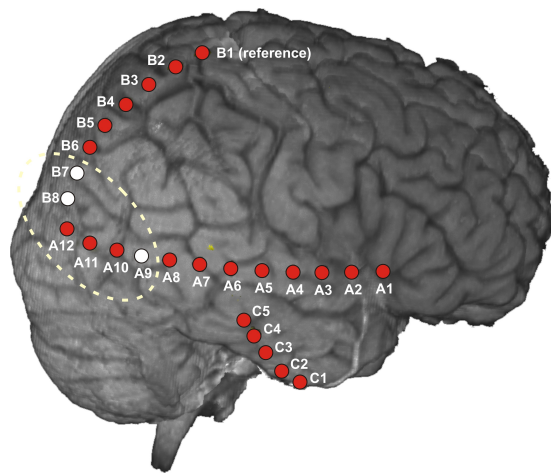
MRI scan with electrode positions. Electrodes revealing initial ictal HFO activity are marked in white (seizure 1: B7, B8; seizure 2: A9). The supposed seizure onset zone is outlined.
